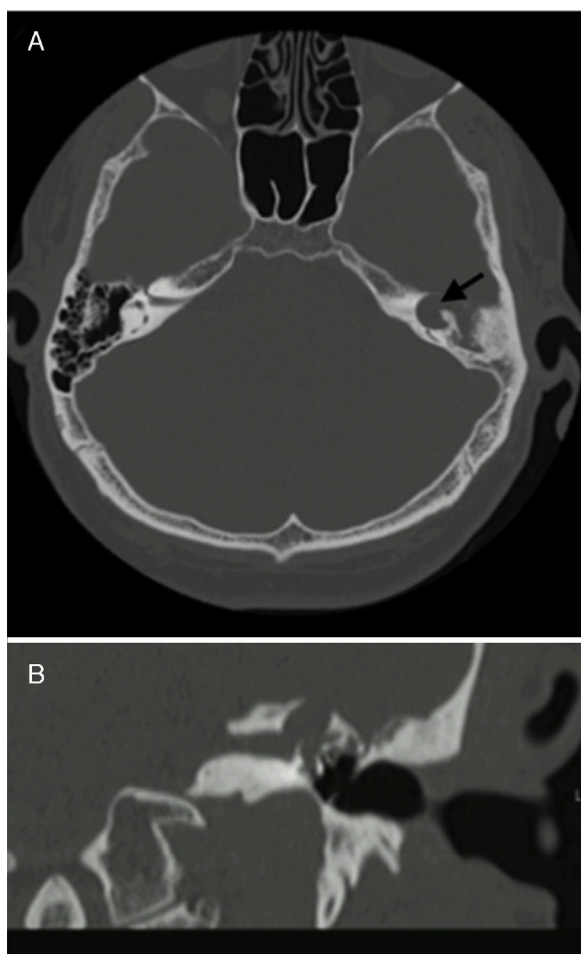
CT of the petrous, congenital cholesteatoma in the geniculate ganglion area. (A) Axial section, involvement of left (arrow) geniculate ganglion. (B) Coronal reconstruction with involvement of the IAC and facial labyrinthine segment.
